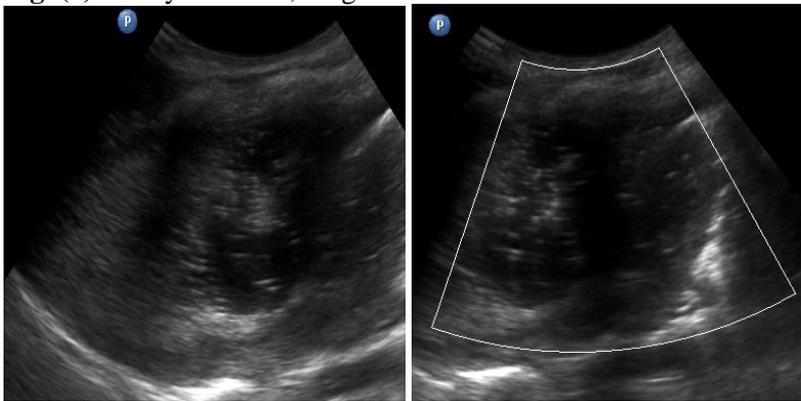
US lung abscess at right lung with a) grayscale image and b) color Doppler image.
